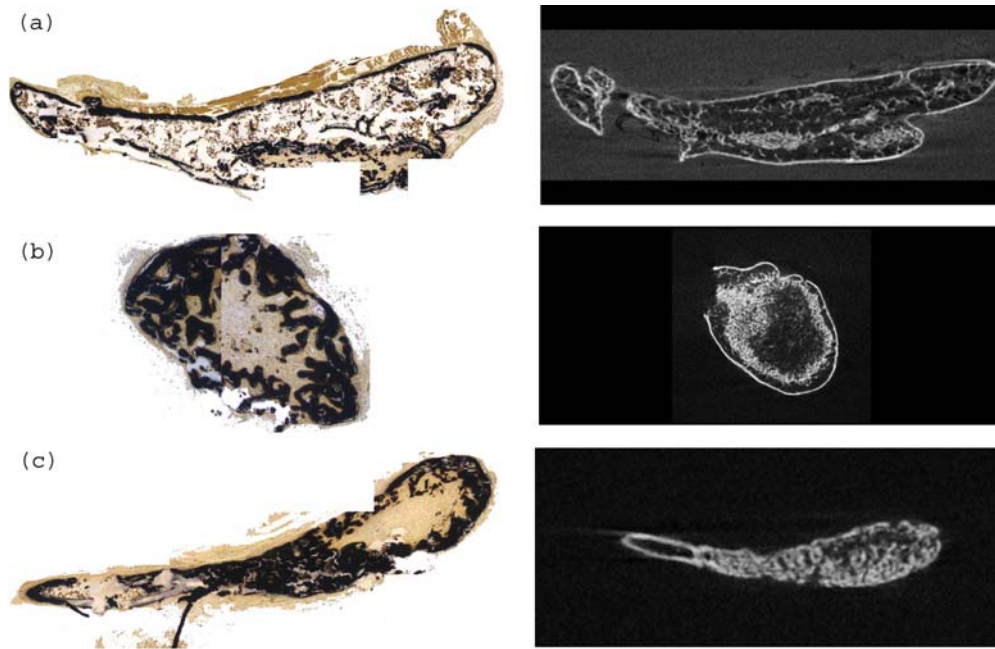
Comparison of von Kossa images that have been stitched together (left) and the analogous μ CT planes (right) at (a) 4 weeks, (b) 8 weeks and (c) 12 weeks for sections of ossicles regenerated from BMSCs.
